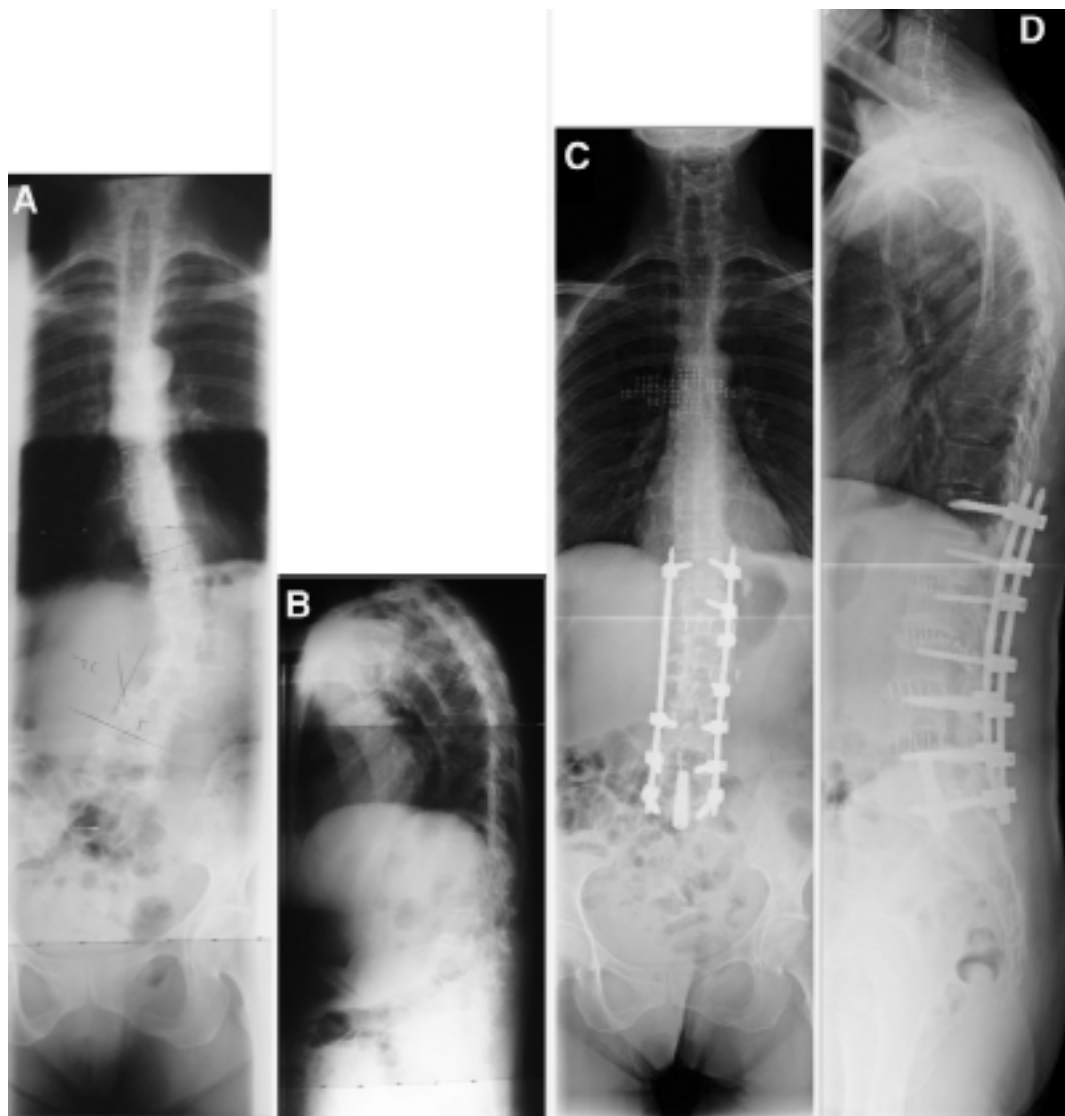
A and B: Preoperative anteroposterior and lateral long-cassette standing radiographs demonstrating ~35° adult lumbar scoliosis, with the apex to the left, in a 61-year-old woman. C and D: The 1-year postoperative anteroposterior and lateral radiographs reveal excellent correction (Cobb angle of 4°), with good sagittal balance.
